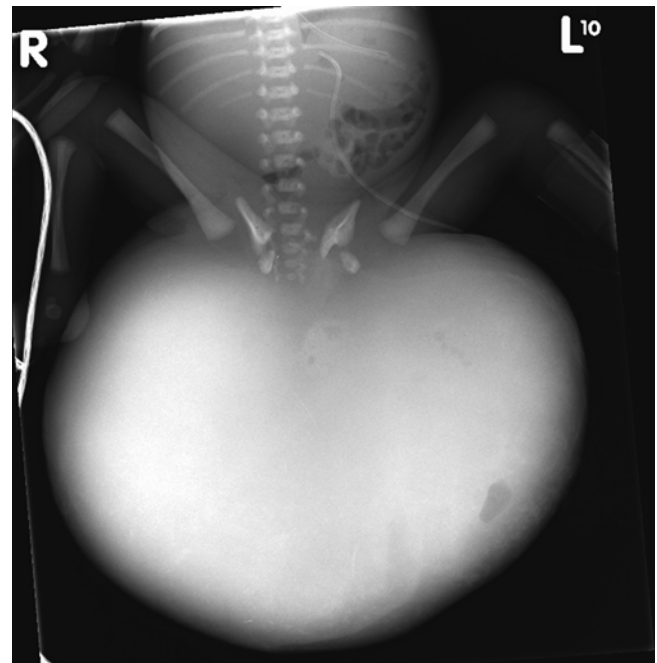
Pelvic radiograph of a neonate showing a huge exophytic sacrococcygeal teratoma splaying the pubic symphysis and the legs
